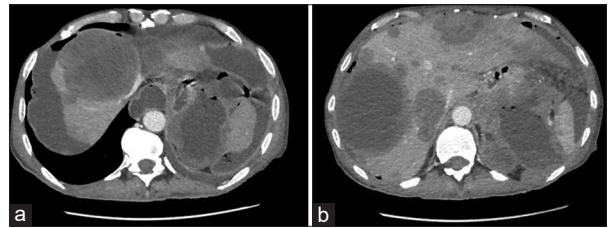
(a) Axial contrast-enhanced abdominal computed tomography (CT) scan reveals free intraperitoneal air (pneumoperitoneum) associated with intra-peritoneal fluid and (b) axial contrast-enhanced abdominal CT scan shows thickening of the gastric wall along the mucosal surface in the proximal body along the greater curvature and bilobar hepatic nodules suggestive of secondary lesions
